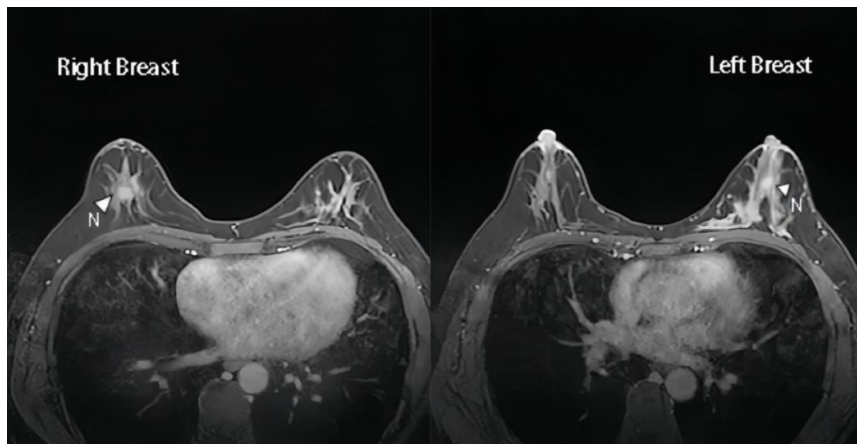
& Figure 4: MRI: Flake-like abnormal signals were seen in the upper inner quadrant of the left breast with unclear boundaries, and the enhanced scan showed obvious enhancement. Nodular abnormal signals were seen directly behind the right breast, with shallow lobulation and burr-like changes at the edge. The enhanced scan showed heterogeneous and obvious enhancement.
